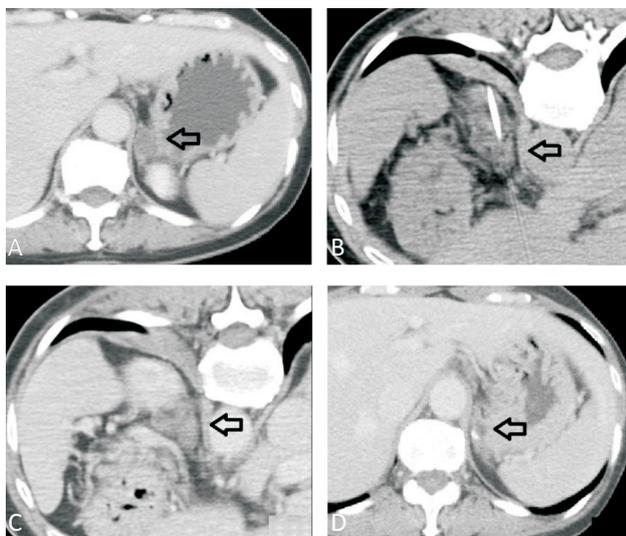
Axial contrast-enhanced computed tomography (CT) images of a 56-year-old woman who presented with resistant hypertension and biochemically-confirmed primary aldosteronism. (a) CT image showing a 2.5-cm left aldosterone-producing adenoma (APA) (arrow). (b) CT-guided percutaneous radiofrequency ablation (RFA) with a paraspinous approach in the prone position – the arrow indicates the RFA needle in the adenoma. (c) Immediate post-RFA CT scan of the same left APA (arrow). (d) CT scan 6 years after RFA – the arrow shows partial calcification with a reduction in APA size.
